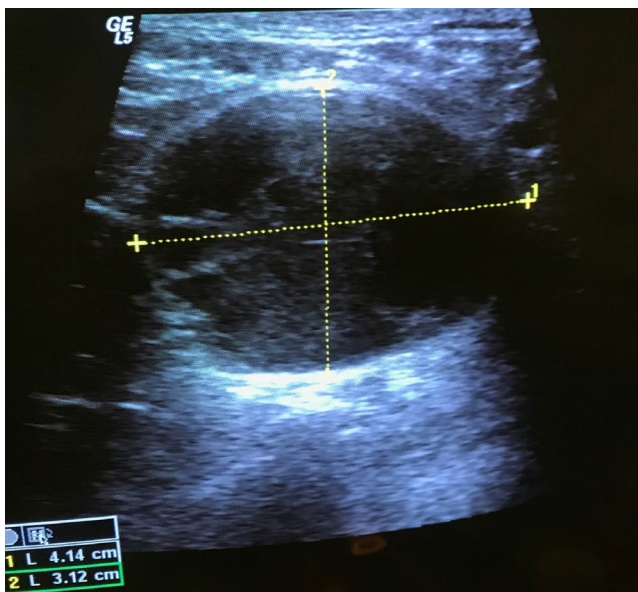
Ultrasound imaging of the cystic mass on the neck
